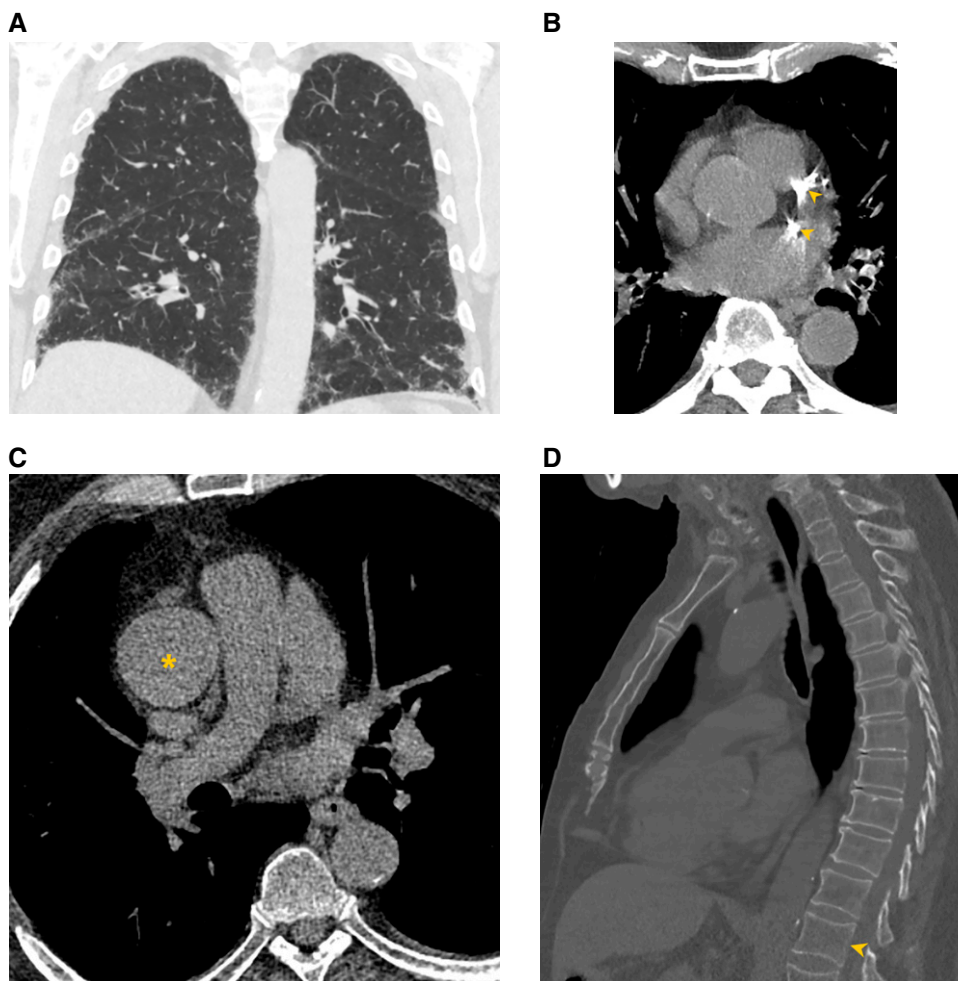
Examples of clinically significant non-chronic obstructive pulmonary disease–related findings on lung cancer screening computed tomography examinations: (A) mild lower lung–predominant fibrotic interstitial lung disease with emphysema, (B) severe coronary arterial calcification (arrowheads), (C) fusiform ascending aorta dilation (asterisk) measuring a maximum diameter of 44 mm, and (D) osteoporosis suggested based on severe diffuse bone demineralization with a density measurement of 57 Hounsfield Units in the L1 vertebral body (arrowhead).
